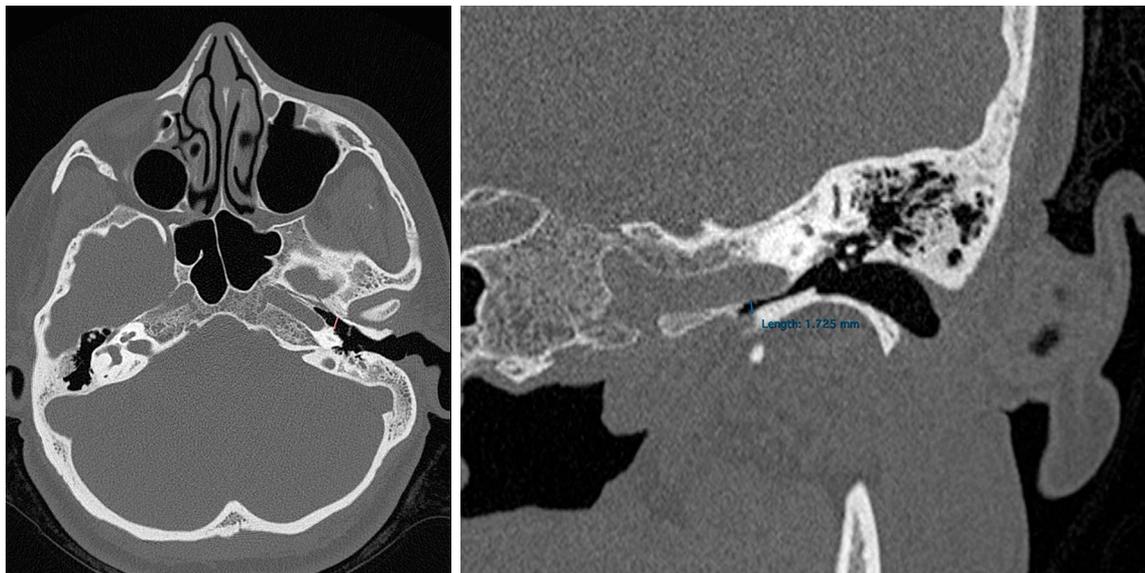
Measurement technique of the eustachian tympanic orifice in axial plane high-resolution CT images (right image) and eustachian isthmus width in coronal plane high-resolution CT images (left image).
